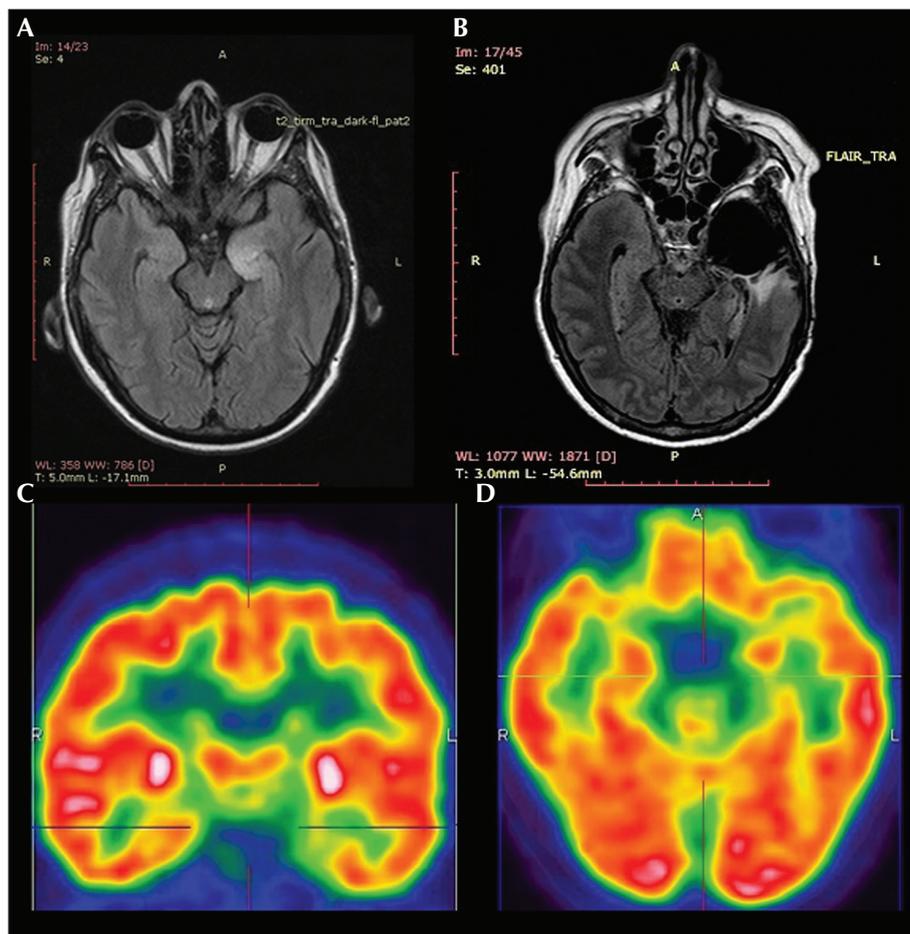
Neuroimaging of MVNT. (A) Preoperative brain FLAIR MRI in axial plane showing a cluster of nodular hyperintense lesions in the left parahippocampal gyrus, extending to the hippocampus and amygdaloid body; (B) postoperative brain FLAIR MRI in axial plane; (C, D) ^{18}F -FDG PET showing a hypometabolic zone in the left mesiotemporal region in coronal (C) and axial (D) plane.
